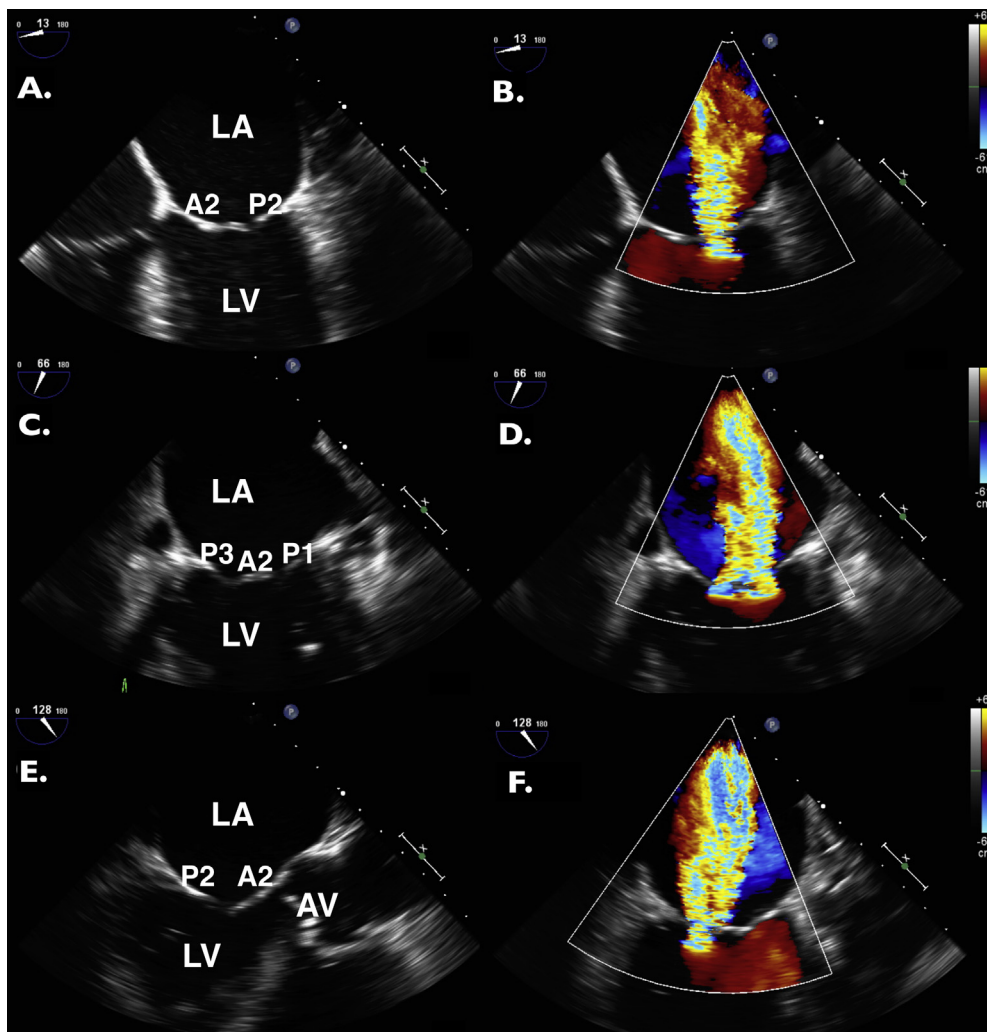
(A) TEE of the ME four-chamber view with A2 and P2 scallops visualized. (B) Corresponding color flow Doppler. (C) TEE of the ME commissural view with P3, A2, and P1 scallops visualized. (D) Corresponding color flow Doppler. (E) TEE of the ME-LAX view with A2 and P2 scallops visualized. (F) Corresponding color flow Doppler. AV, Aortic valve.
